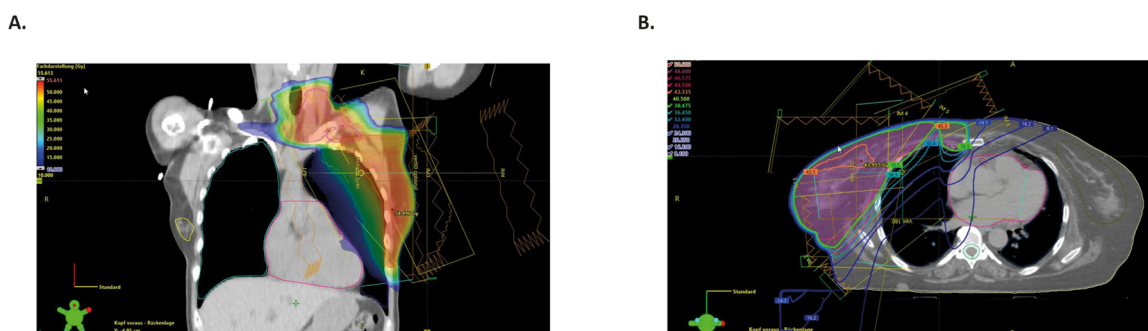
Treatment planning CT-scans. Treatment plans for breast cancer irradiation. Figure 3.A shows a modern treatment plan of a female patient undergoing left-sided breast and regional nodal radiotherapy using a 4-field sliding window technique Figure 3.B shows a female patient undergoing right-sided breast and regional nodal radiotherapy including supra-/infraclavicular and internal mammary lymph nodes after breast-conserving surgery using a 5-field sliding window IMRT. (Reprinted with permission from Haussmann et al.⁶⁰)
